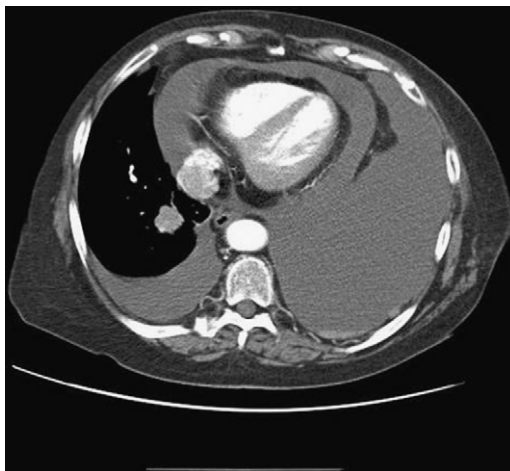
CT scan showing large pericardial effusion and bilateral pleural effusions.
